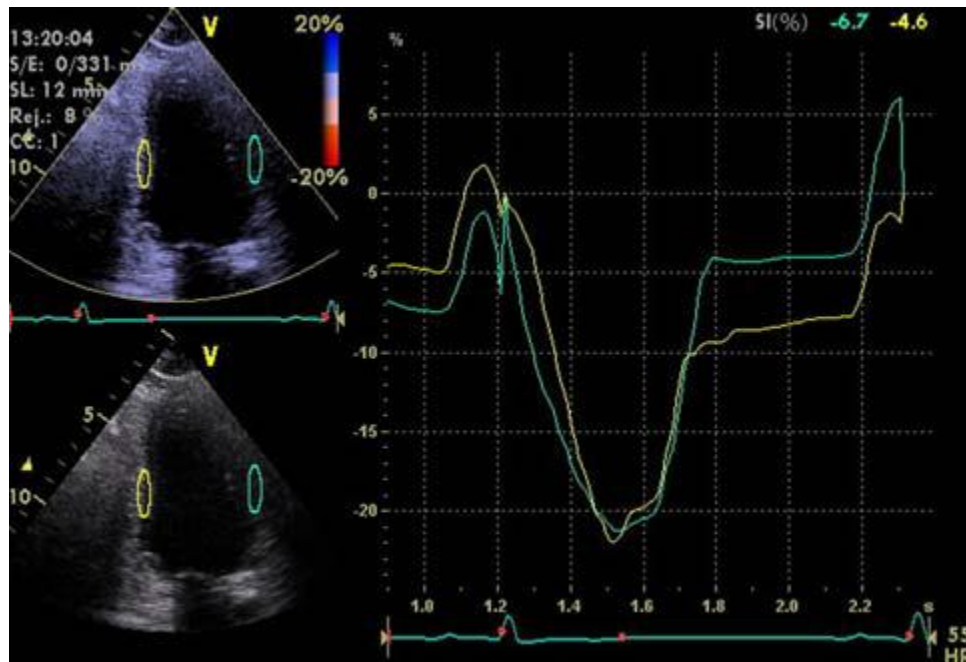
An exemplar scan from a colour tissue-Doppler assessment of regional wall strain and strain rate in the apical four-chamber view (note the apical LV view and longitudinal tissue strain traces measured in the septal and free wall at the mid-wall level).
